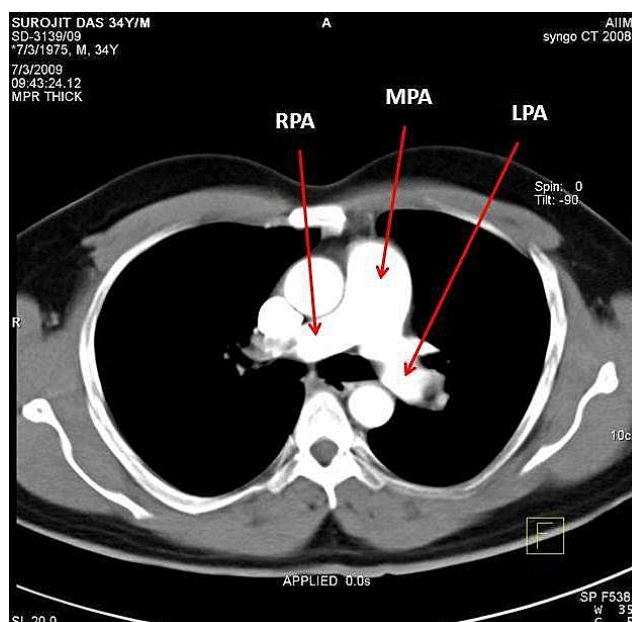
CT angiography showing that the MPA, proximal RPA and LPA are free of thrombi but showing thrombi as filling defects in distal parts of RPA and LPA
